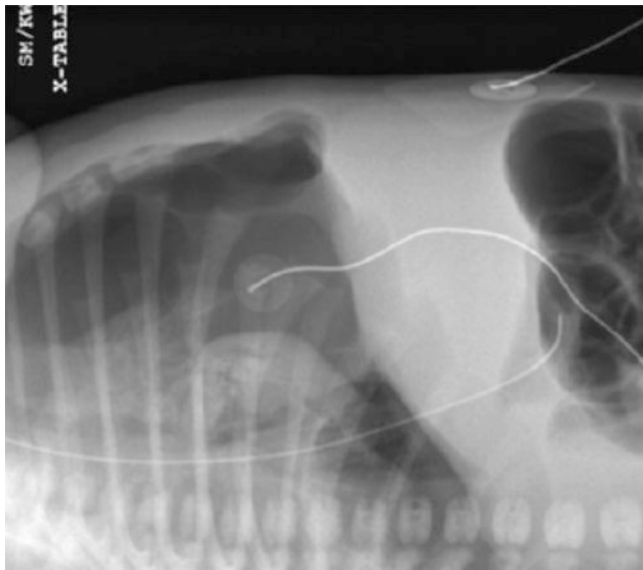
Cross-table lateral chest radiograph shows a moderate-sized pneumothorax anteroinferiorly
